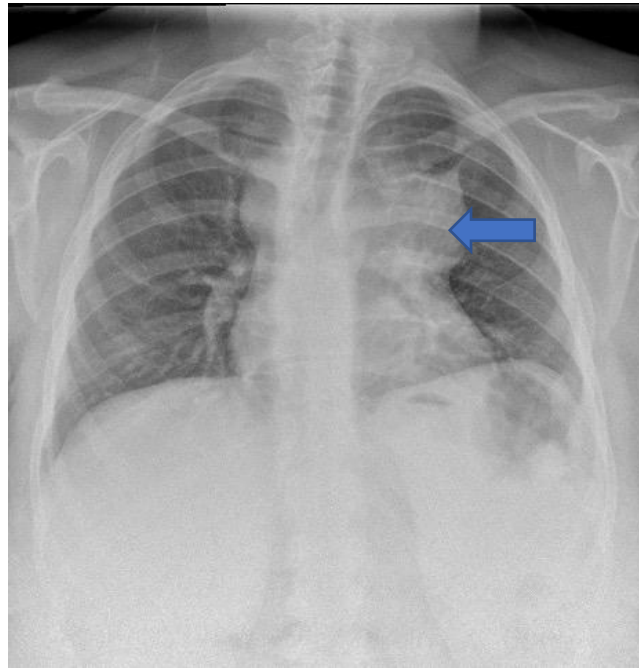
25 year old female presenting with shortness of breath. Plain radiograph showing a left anterior mediastinal mass (blue arrow).
